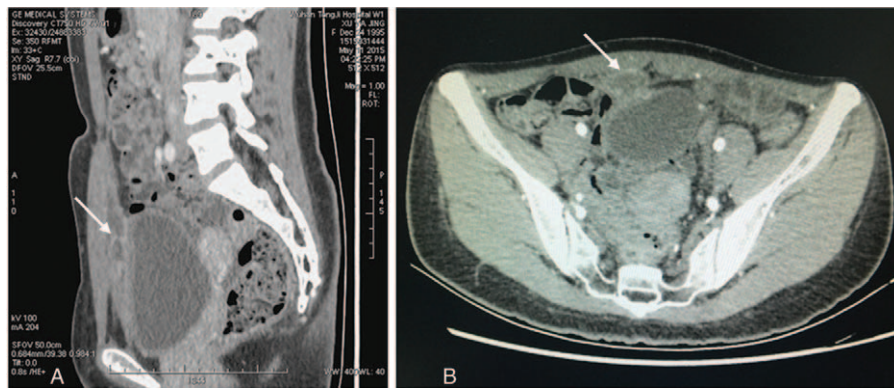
Abdominal enhanced CT scans show urachal cyst (arrow) in the subumbilical region with abscess formation. (A) Coronal view. (B) Transverse view.
